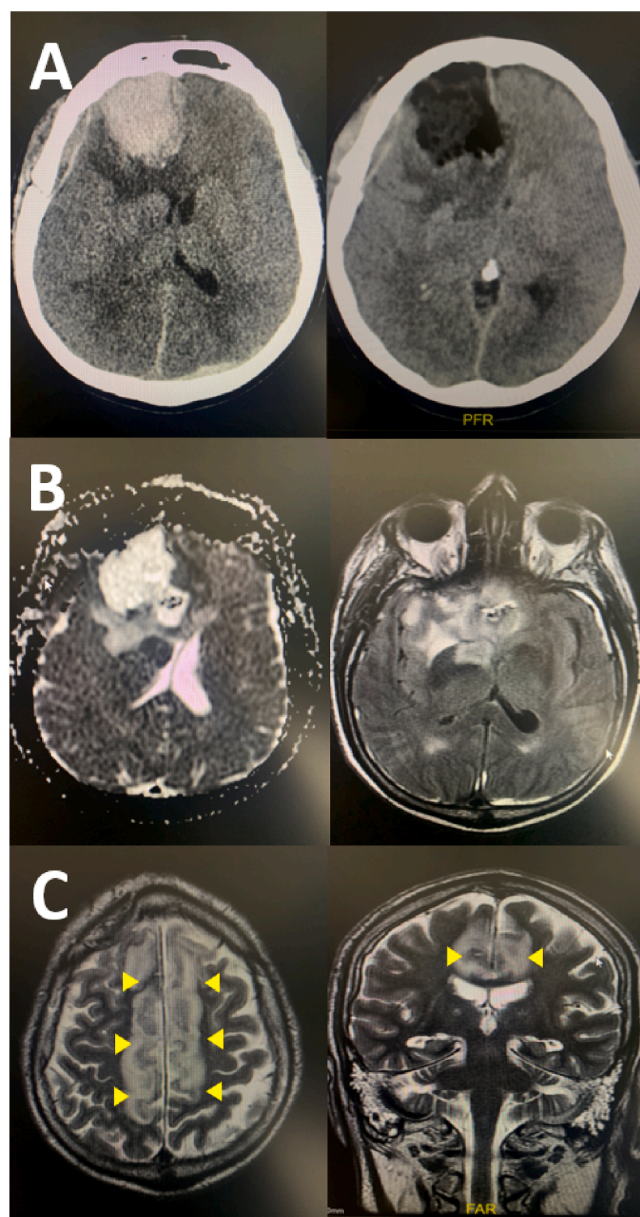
Case 1. A: Pre and postoperative brain CT scan showing right frontal intraparenchymal hematoma associated to mass effect and after surgical drainage, respectively. B: Day 3 brain MRI showed a stroke of head of the caudate nucleus. C: Week 2 brain MRI showing frontal, parietal and occipital bihemispheric infarcts due to superior sagittal sinus thrombosis.
